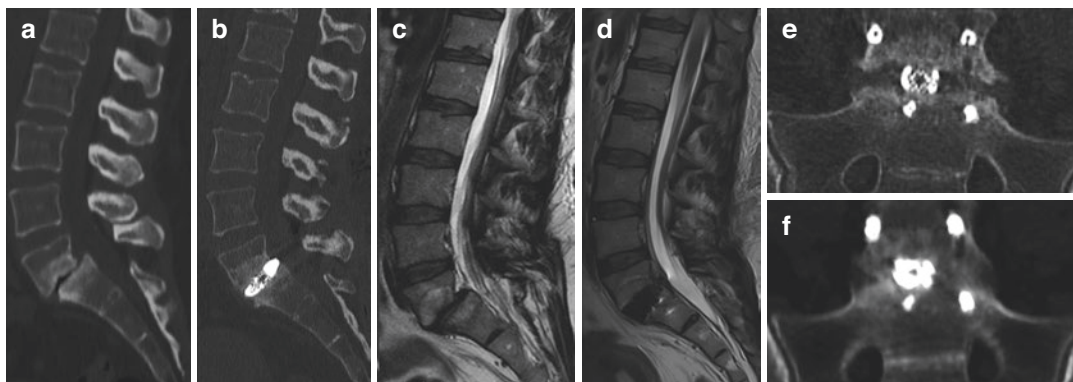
Demonstrative pictures regarding L5–S1 UBE-TLIF. (a) A L5–S1 spondylolisthesis grade 1 with endplates swelling is observed in the sagittal view of the lumbar CT. (b) First-week postoperative lumbar CT on a sagittal view. The interbody device was placed at L5–S1.
